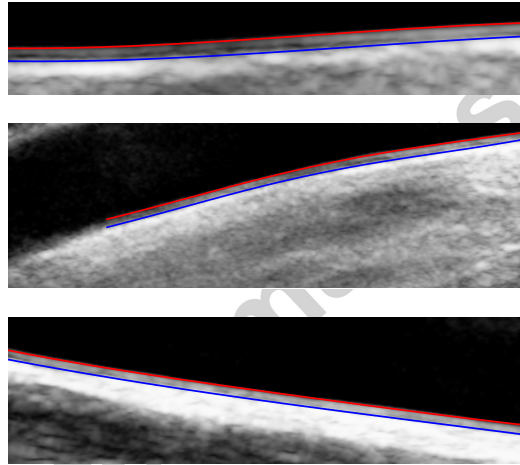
Different examples of good segmentation. The proposed method is robust against the orientation and appearance of the CCA in the ultrasound image
